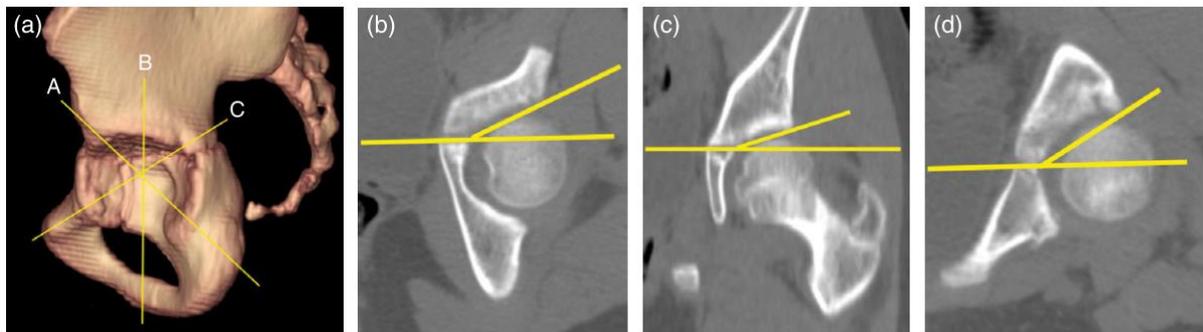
from left to right; a. the reconstructed CT scan showing the 3 cutting planes for the 3 slices; b) anterosuperior plane with marked angle; c) superolateral plane with marked angle; d) posterosuperior plane with marked angle<sup>43</sup>.
